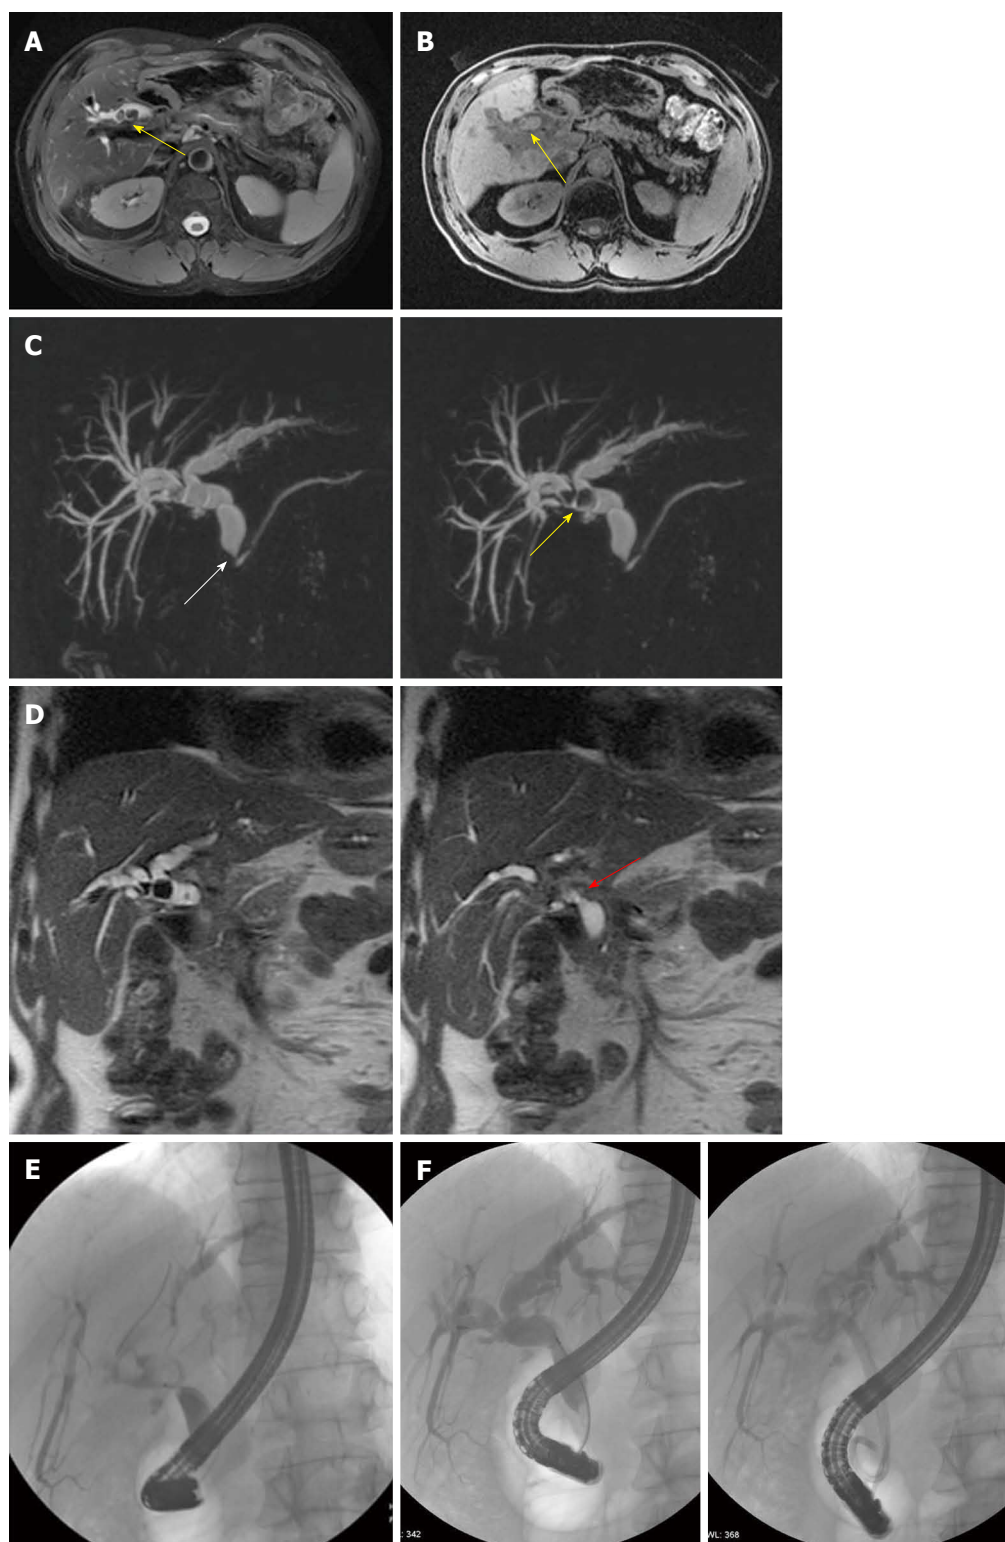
Anastomotic biliary stricture with lithiasis. A: Axial T2-weighted image shows dilation of the biliary system with concomitant stones (yellow arrow); B: Axial T1-weighted image confirms the presence of stones in the biliary tract (yellow arrow); C: Maximum intensity projections of 3D thin-slab fast spin-echo T2-weighted images (obtained using different thicknesses) demonstrate the dilation of the both intra- and extra-hepatic (pre- and post-anastomotic) biliary tract with a stricture of the iuxta-papillary choledochus (white arrow); the presence of two stones at the level of the hepatic bifurcation (yellow arrow) is also well appreciable; D: On coronal single-shot T2-weighted images (at different levels) is also better appreciable a stricture at the anastomotic site (red arrow); E: Endoscopic retrograde cholangiography confirms the presence of strictures and stones in the pre-anastomotic biliary tract; F: Stones were endoscopically removed and strictures were treated by stenting as shown on different projection images.
